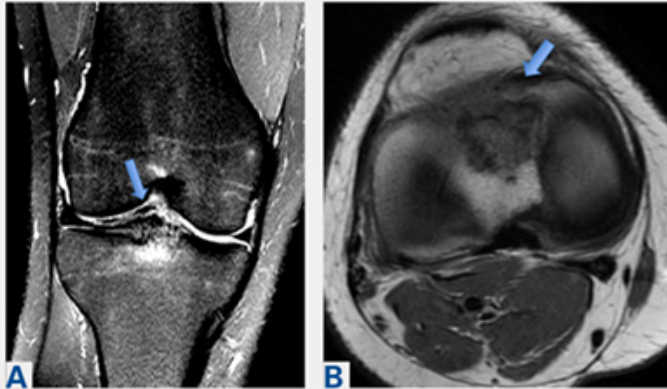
(A) Coronal and (B) axial magnetic resonance imaging demonstrating the anterior root of the lateral meniscus (arrows) attached to the displaced fracture fragment.
